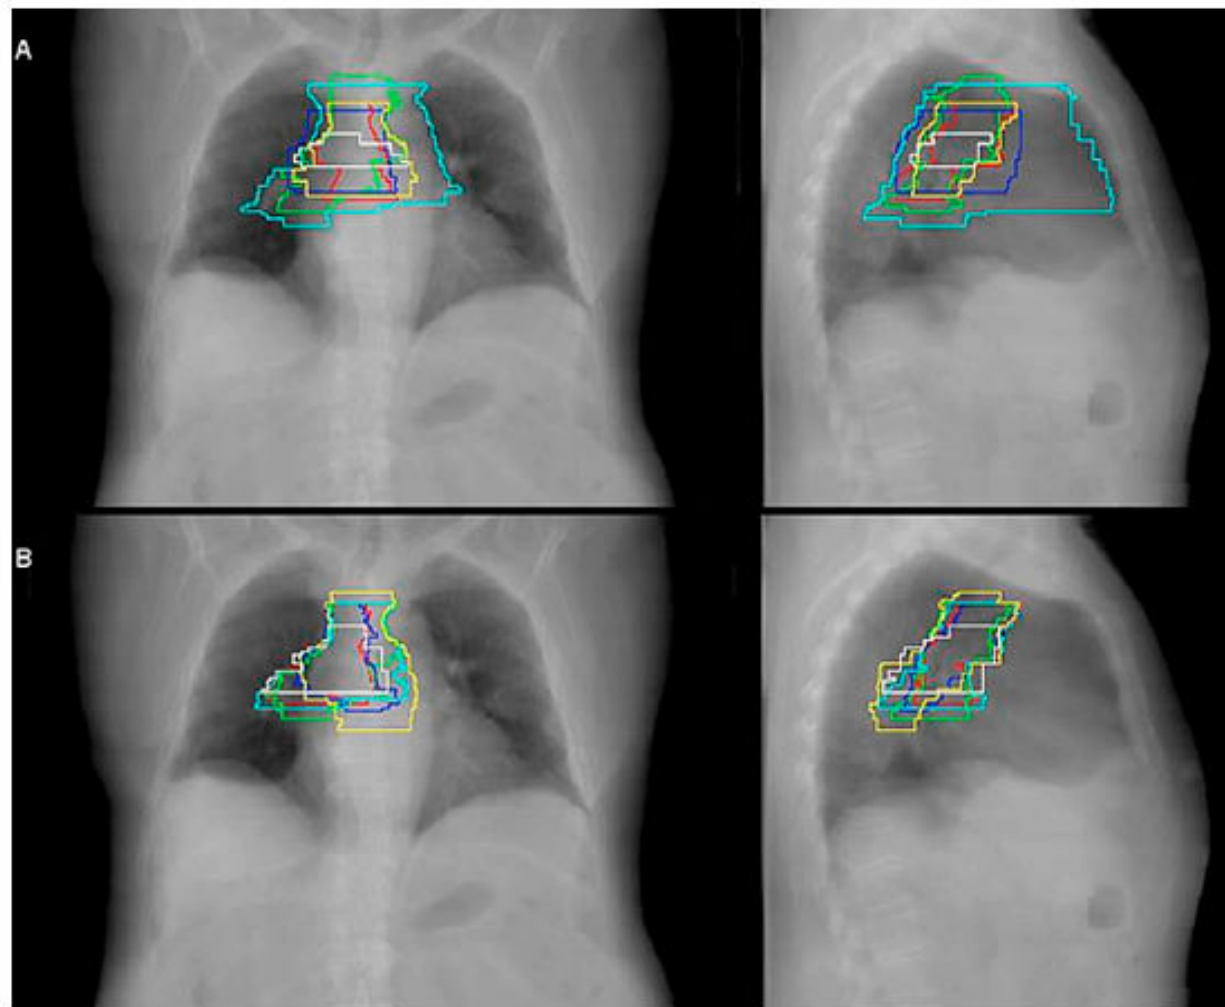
Routine clinical target volumes (CTVs) (upper panel) and protocol CTVs (lower panel) from six observers projected on a digital reconstruction of a computed tomography dataset from the postlobectomy patient.
